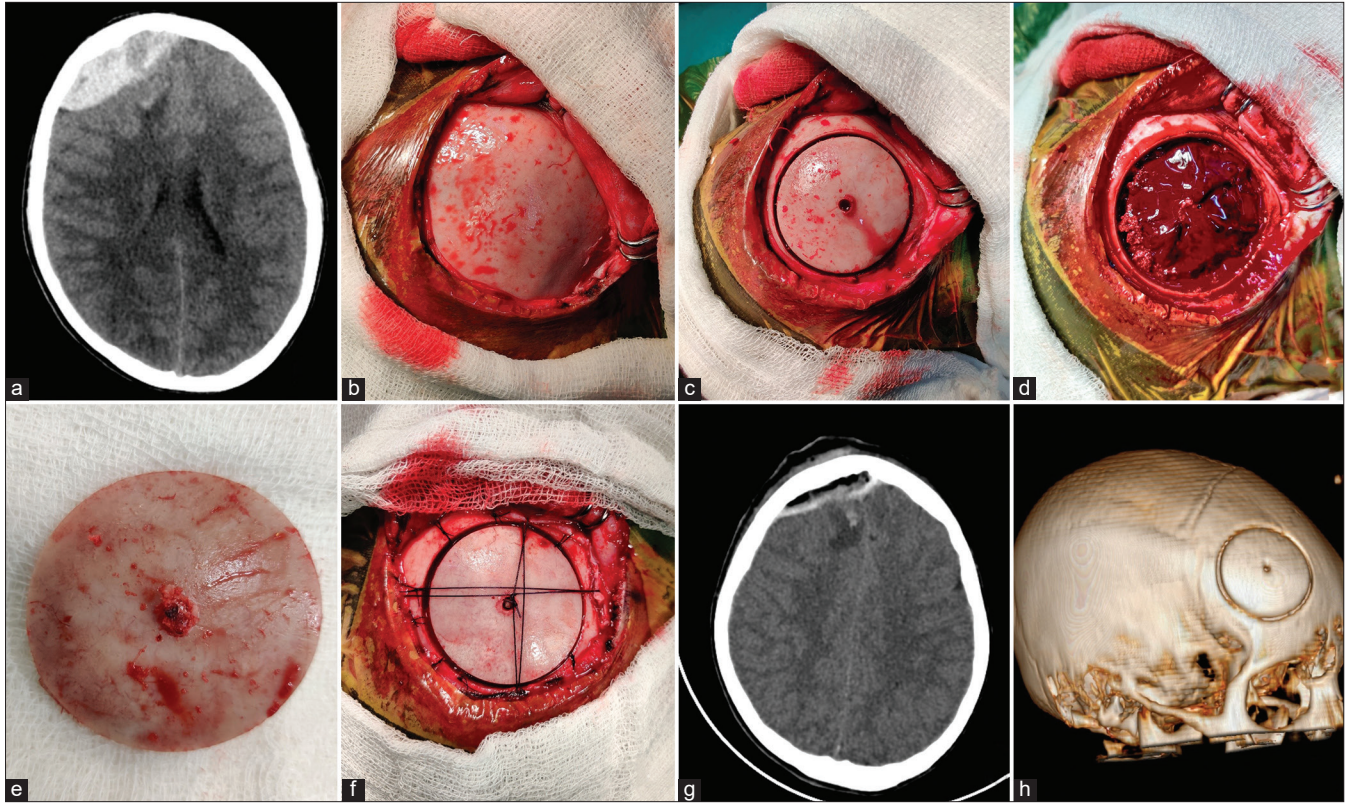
NCCT head showing right frontal extradural hematoma (EDH) crossing midline extending toward left (a), intraoperative photographs exposure of the right frontal bone (b), trephination *in situ* (c), EDH seen (d), the central pinhole on the outer cortex of the bone flap which is an initial fixation point for trepan (e), EDH evacuated and bone flap fixed using sutures (f), postoperative CT scan showing resolution of EDH (g), and postoperative 3D reconstructed image (h).
